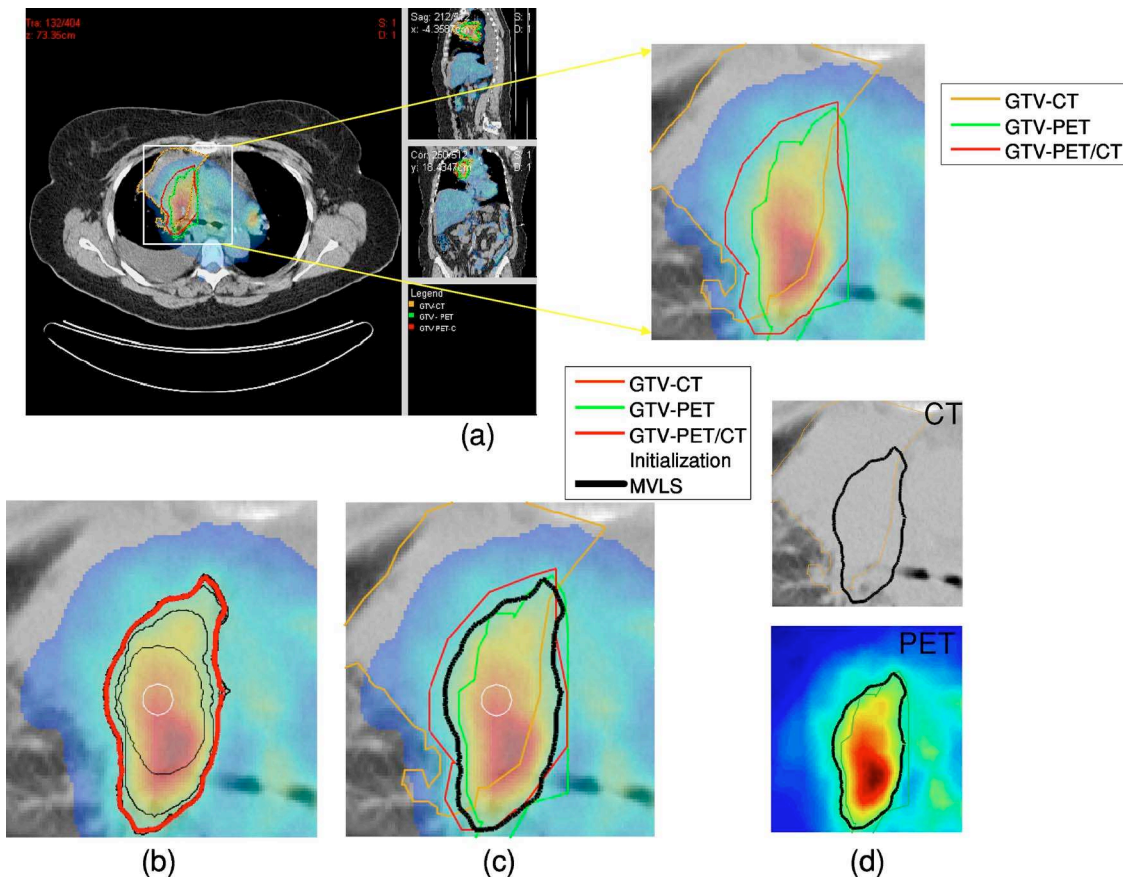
Analysis of lung PET/CT case. (a) A fused PET/CT displayed in CERR with manual contouring shown of the subject's right gross tumor volume. The contouring was performed separately for CT (in orange), PET (in green), and fused PET/CT (in red) images. (b) The MVLS algorithm was initialized with a circle (in white) of 9.8 mm diameter, evolved contour is steps of ten iterations (in black), and the final estimated contour (in thick red). The algorithm converged in 120 iterations in a few seconds. The PET/CT ratio weighting was selected as 1:1.65. (c) MVLS results is shown along with manual contour results on the fused PET/CT. Note the agreement of fused PET/CT manual contour and MVLS (DSC=0.87). (d) MVLS contour superimposed on CT (top) and PET (bottom) separately.
